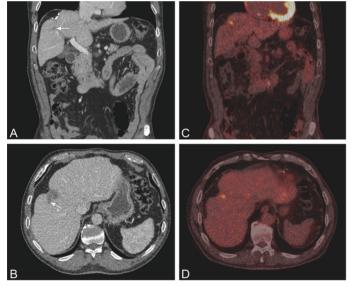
Recurrent disease after liver RFA. Images of CT (A, B) and PET/CT (C, D).
